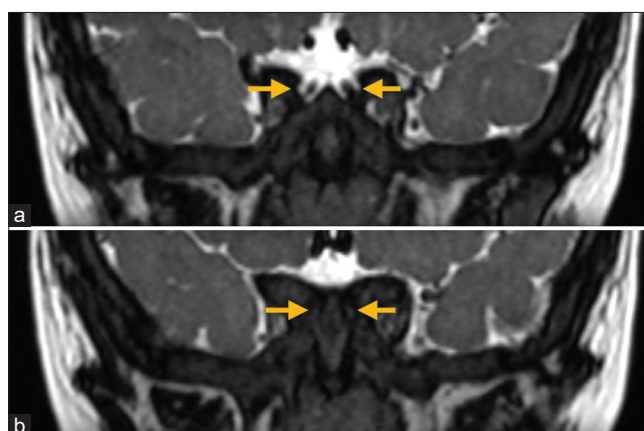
Coronal view of cube magnetic resonance imaging, T2 3-D reconstruction, (a) Bilateral optic canal stenosis (arrows), more severe at the right side, (b) bilateral optic nerve atrophy (arrows), where the diameter of optic nerves are extremely small
